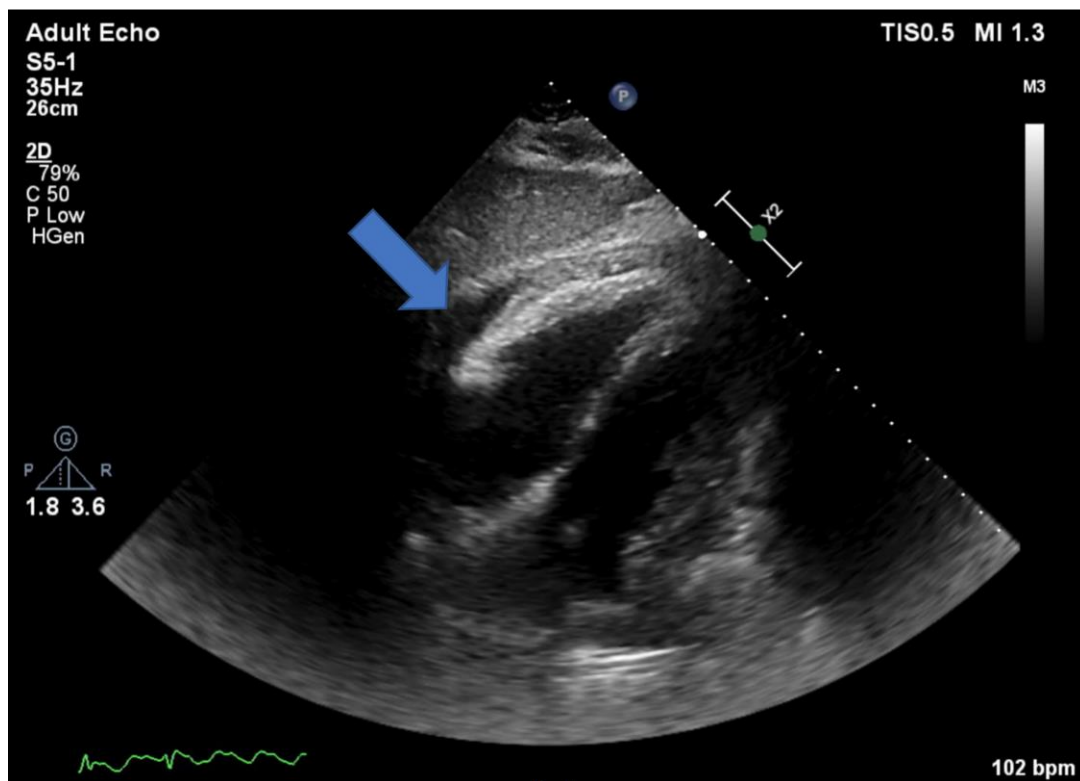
Transthoracic echocardiography, subcostal window, showing prominent epicardial fat and pericardial effusion (blue arrow).
